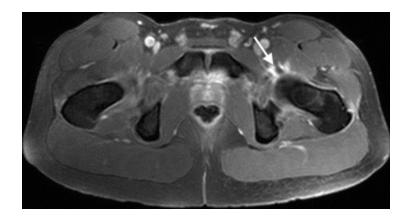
Axial contrast-enhanced T1-weighted SPIR pelvic MRI shows hypersignal at the myotendinous junction of the iliopsoas (arrow)
